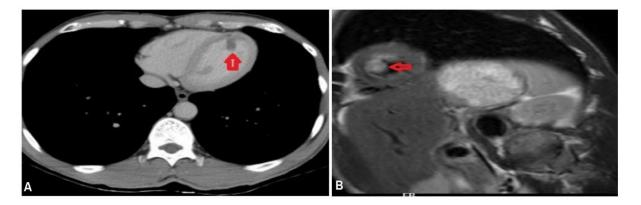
A: Contrast-enhanced computed tomography scan with the arrow showing well-defined oval nonenhancing filling defect with smooth margins adjacent to the apex of the left ventricle possible thrombus. B: Cardiac MRI showing transmural (non-viable) infarct involving the anterior septum in apical and mid cavity level with apical thrombus.
